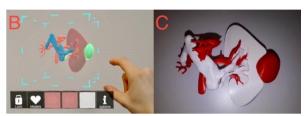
Three different visualization techniques for the MRI-based 3D models of patient 3. The patient has a transposition of the inferior vena cava below the superior mesenteric artery. A = 2D screenshot of 3D rendering in 3DSlicer with a coronal T2-weighted MRI slice; B = Augmented Reality through the head-mounted display (HoloLens), holding the blue "cube" allows for translation of the hologram; C = 3D printed model printed with polylactid acid in an Ultimaker S5, the kidney is bisected.
